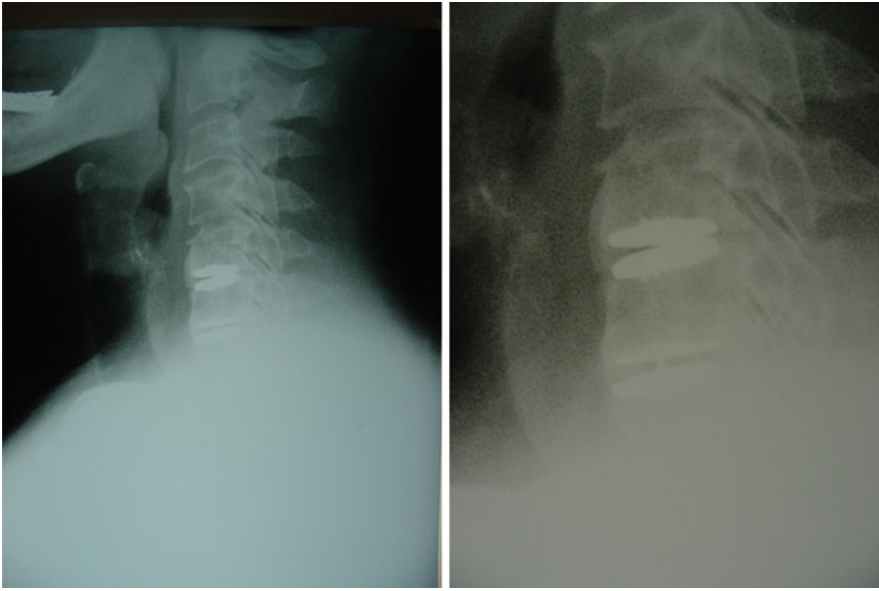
The MOBI-C[®] is visualized on these lateral radiographic views of the cervical spine. This patient presented with loss of motion and radiographic evidence of heterotopic ossification at the index surgical levels (C5-C6 and C6-C7). These images demonstrate the imaging
